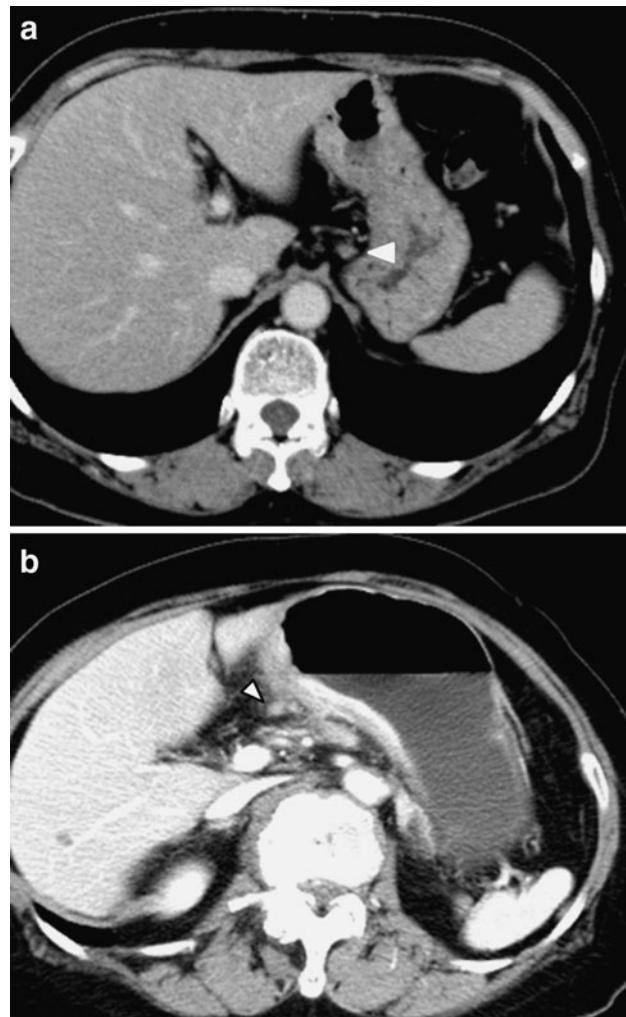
Representative CT pictures of false-positive lymph node metastasis by single-detector CT and true-positive metastasis by 64 MD-CT. a False-negative case; 8-mm lymph node along the lesser curvature (#3) was detected by single-detector CT, but it was not actually a lymph node with metastasis (arrowhead). b True-positive case; 8-mm infrapyloric lymph node (#6) was detected by 64 MD-CT, and it was pathologically diagnosed as a metastatic lymph node (arrowhead)
